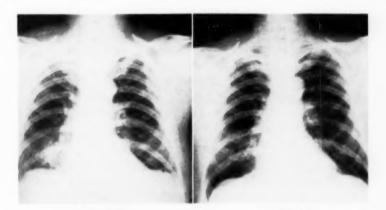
Roentgenogram of February 12, 1951, showing infiltration in right lung. Figure 4: Roentgenogram of April 30, 1951, showing almost complete resolution.
